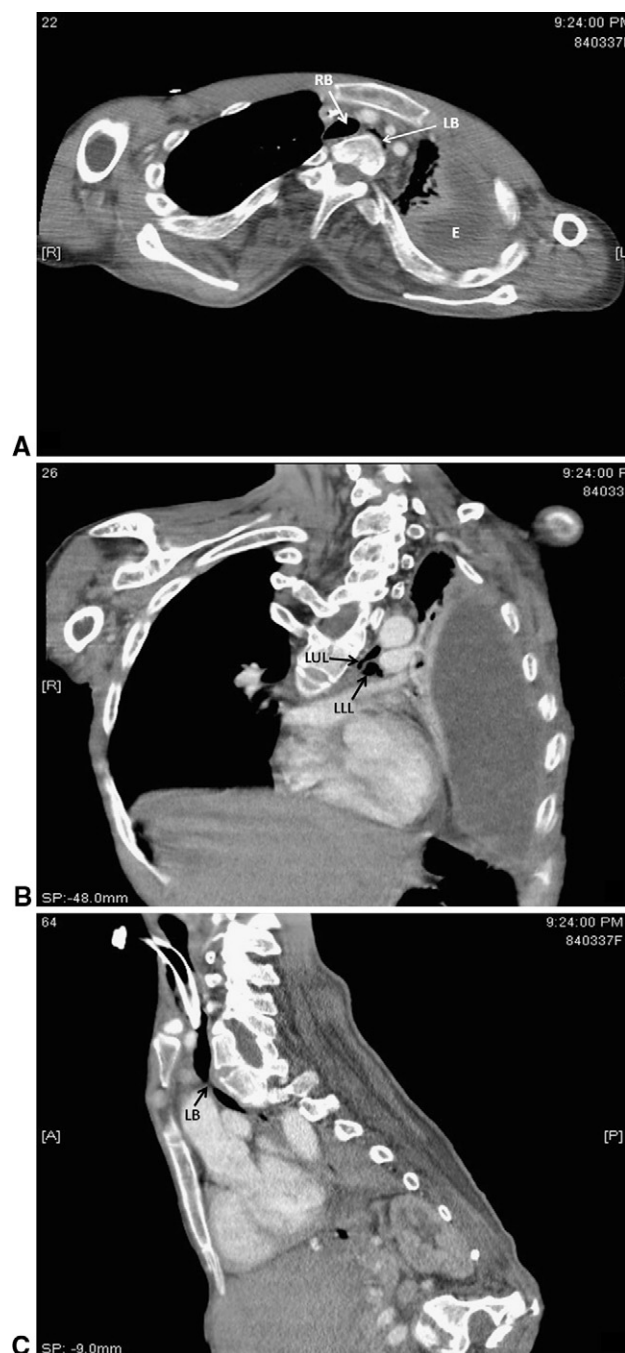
A, Chest computed tomography scan (axial view) showing significant left main bronchus narrowing. RB, Right bronchus; LB, left bronchus; E, empyema. B, Chest computed tomography scan (coronal view). LUL, Left upper lobe bronchus; LLL, left lower lobe bronchus. C, Chest computed tomography scan (sagittal view). LB, Left bronchus.
